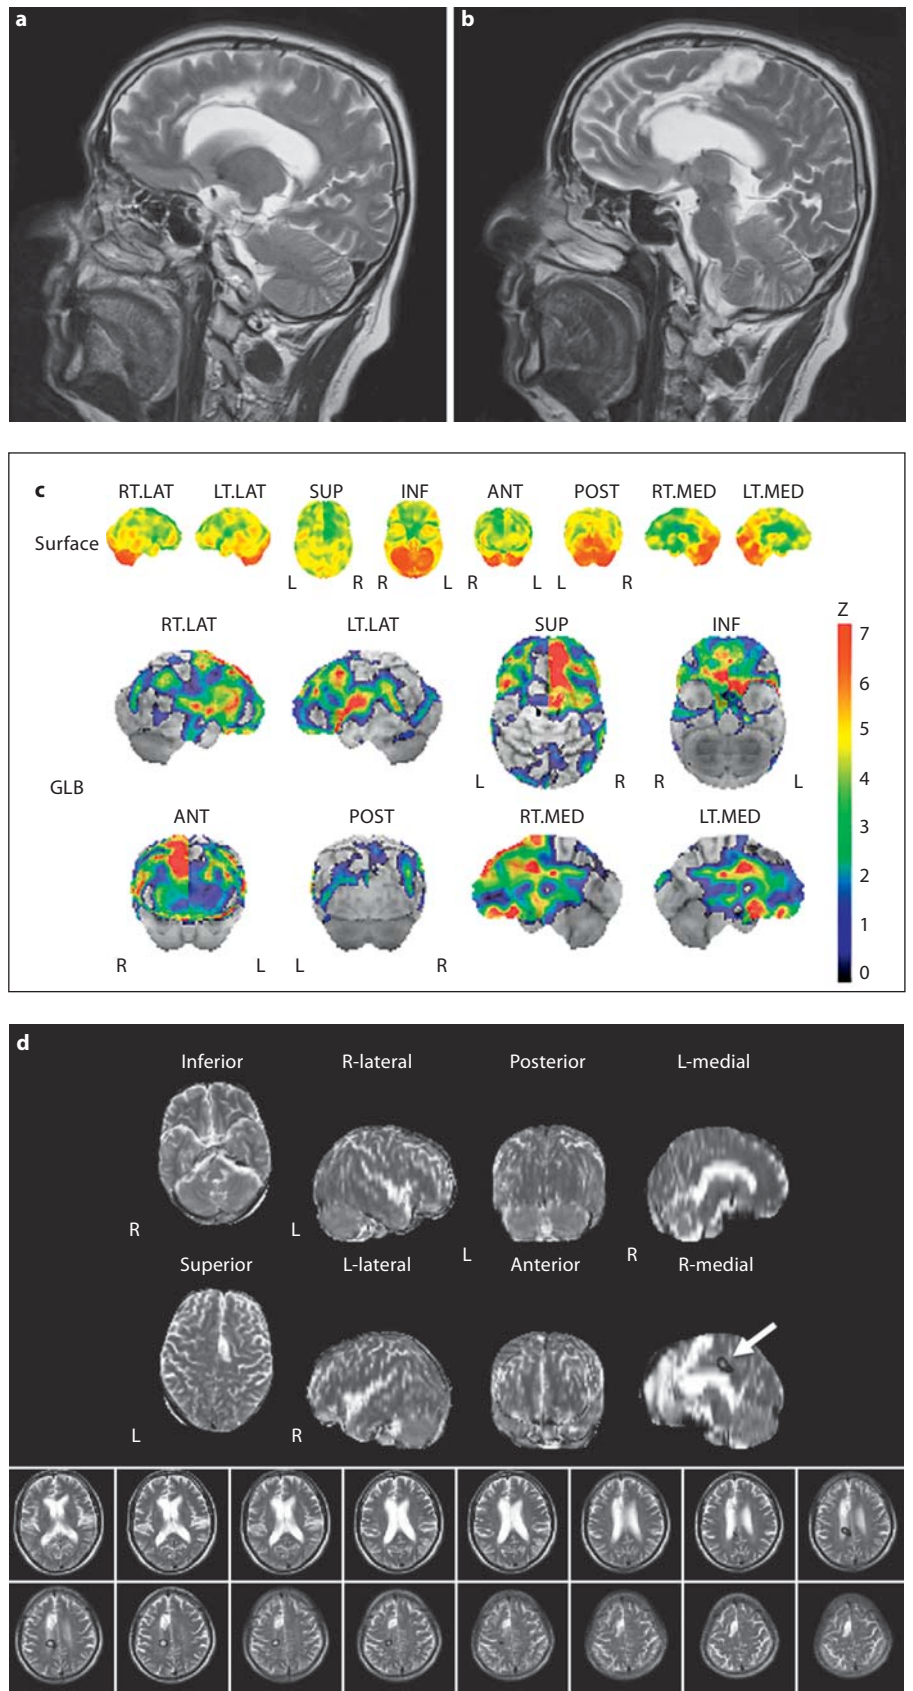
a, b Sagittal T2-weighted magnetic resonance images show increased signals in the right frontal lobe, anterior cingulate gyrus, and corpus callosum extending from the genu to the anterior part of the truncus. c Brain ^{123}I -IMP SPECT at 2 months after stroke (3-dimensional stereotactic surface projection). The SPECT findings show decreased cerebral blood flow in bilateral frontal lobes, the cingulate gyrus, and the corpus callosum, with remarkable hypoperfusion in the right frontal lobes. d Subtraction SPECT findings coregistered with MRI results. The SPECT findings obtained 2 months after stroke onset were subtracted from the SPECT findings obtained 20 months after stroke onset. The SSCOM images demonstrated a significant increase in cerebral blood flow in the posterior truncus of the right corpus callosum.
